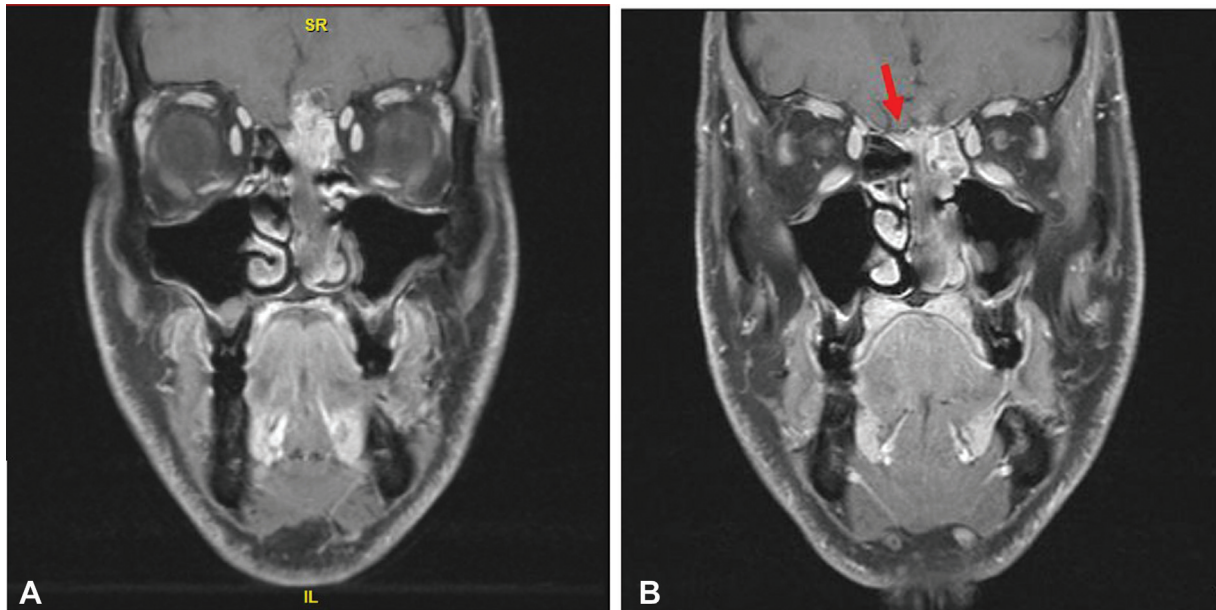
(A) Case presentation of coronal magnetic resonance imaging, T1 postgadolinium. (B) Arrow indicates contralateral olfactory tract involvement.
